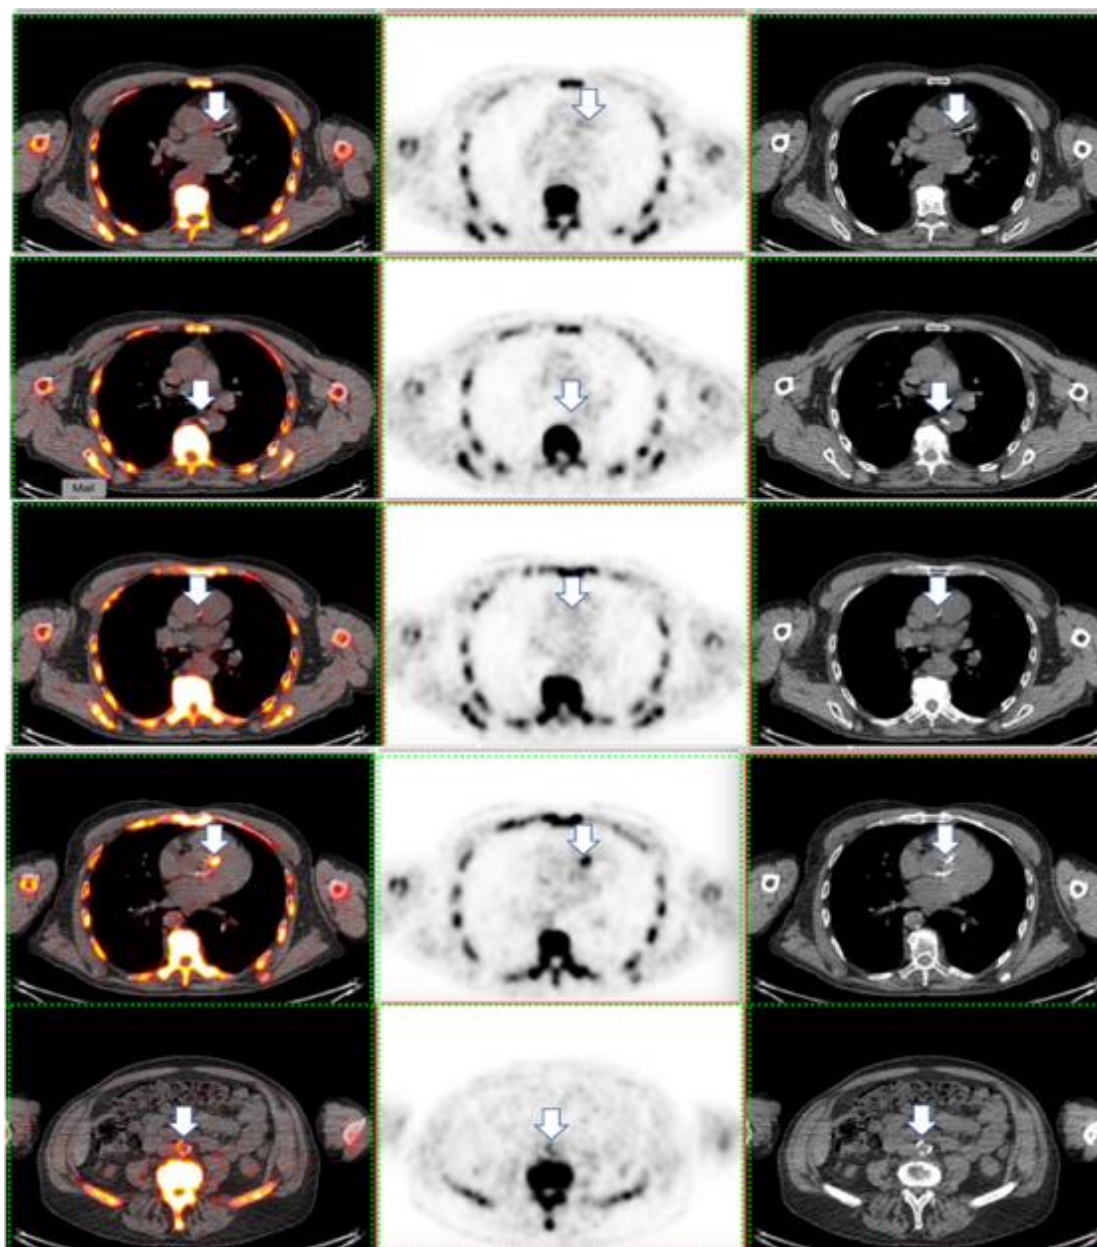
Axial ^{18}F -NaF PET/CT images for a 62 year old, male AKU patient.
